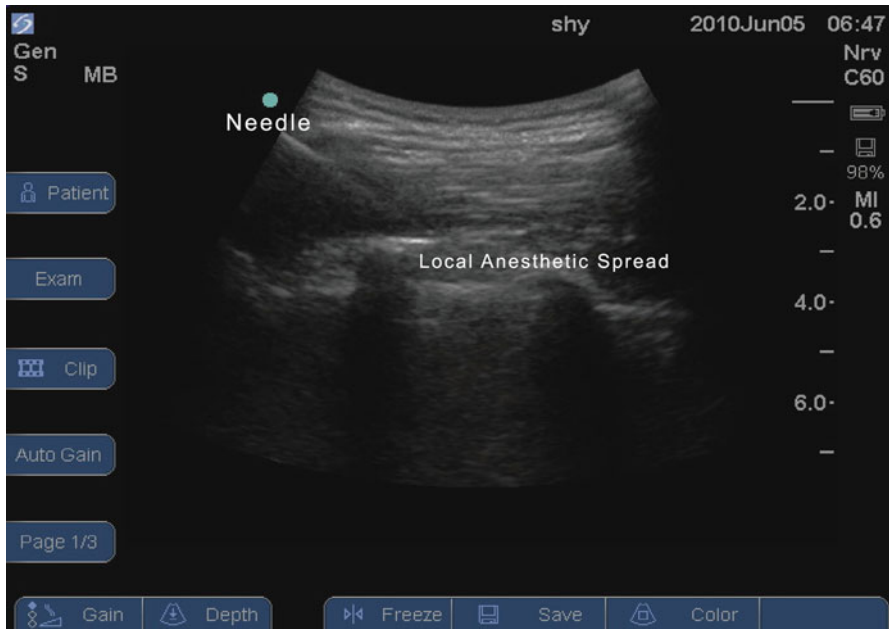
Please note the needle positioned to the left of ultrasound image, the spread of local anesthetic in the paravertebral space, and tenting of the pleura
